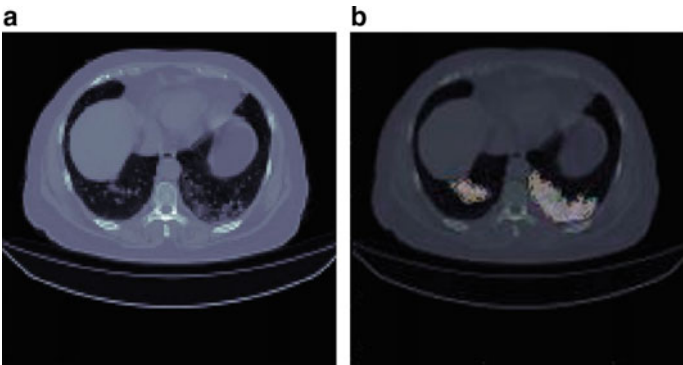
Steps involved in the segmentation of lung CT scan images using Covi-Net model
